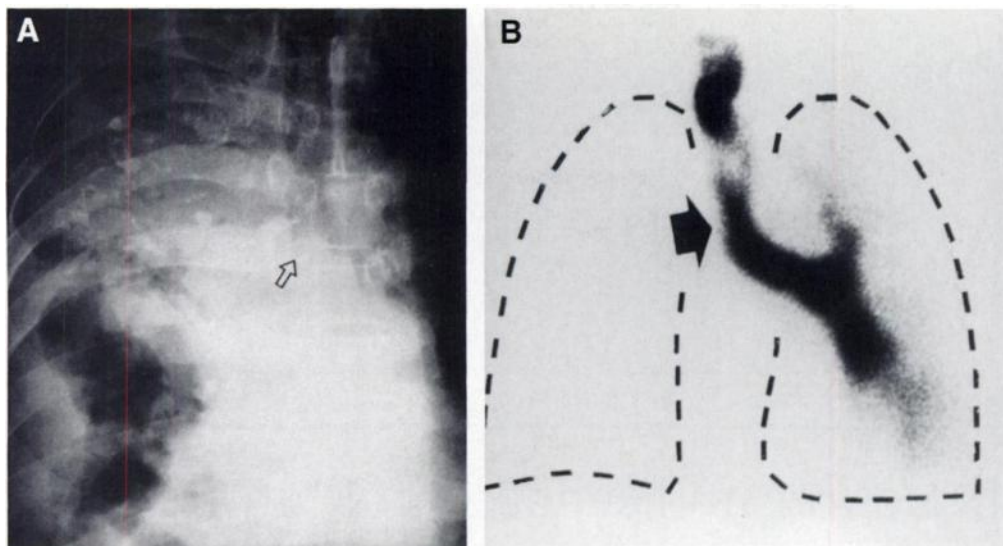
Modified, prestenotic aerosol deposition in the trachea in a 69-yr-old man with advanced tuberculosis and right main-stem bronchus carcinoma. (A) High-penetration, posteroanterior chest radiograph shows obstruction (open arrow). (B) Anterior aerosol scan reveals complete obstruction of the right main-stem bronchus with an intense tracer deposition in the trachea and left main-stem bronchus due to tracheal damage, disturbed transport and excess of aerosols, respectively (arrow). This is considered to be a case of modified, prestenotic aerosol deposition.
